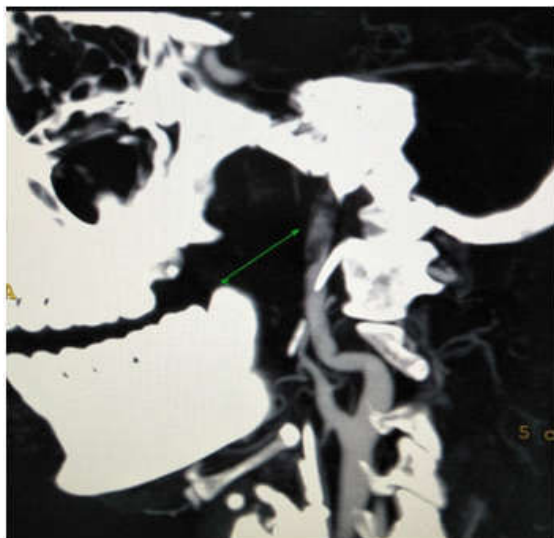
CT Angio Right side
